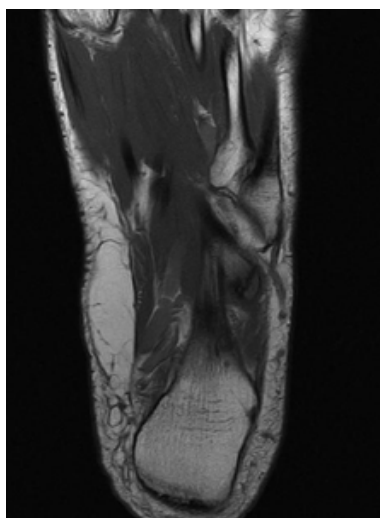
Axial MRI of left foot with rupture of peroneus longus at the level of os peroneum.
